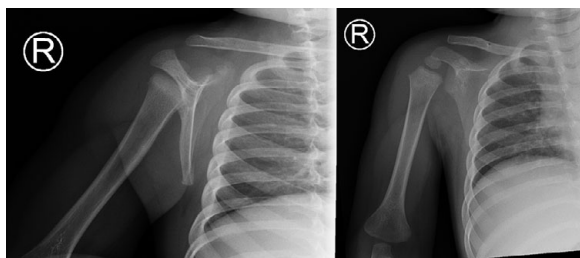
Anteroposterior (AP) and lateral radiographs shoulder
